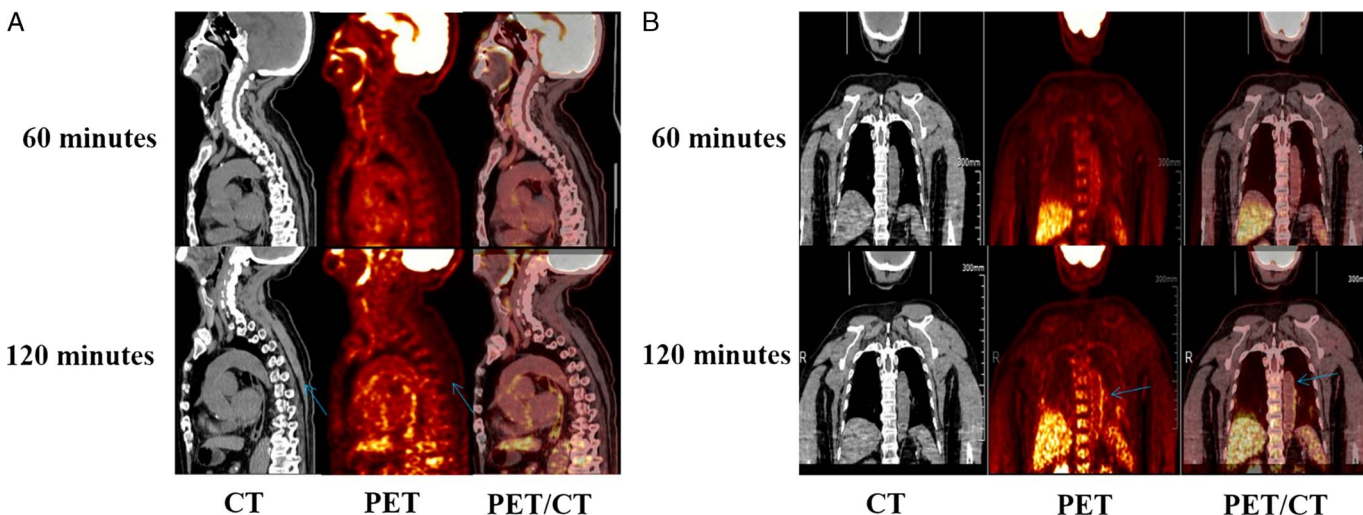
Delayed imaging provides more accurate diagnostic information. A 19-year-old girl with Takayasu arteritis underwent FDG PET/CT (dose 3.7 MBq/kg, acquisition time 15 minutes) to evaluate status of inflammation. PET images acquired 2 hours (A) and 5 hours (B) after FDG injection. The blood pool activity decreases (SUVmean 1.06–0.63), whereas the aortic wall FDG avidity increases (SUVmean from 1.61 to 2.00). The ratio between aortic wall and blood pool activities increases from 1.57 to 3.17. Reproduced with permission from Sui et al.<sup>25</sup>
